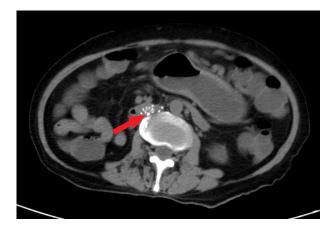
CT image of *in situ* inferior vena cava filter (red arrow)
